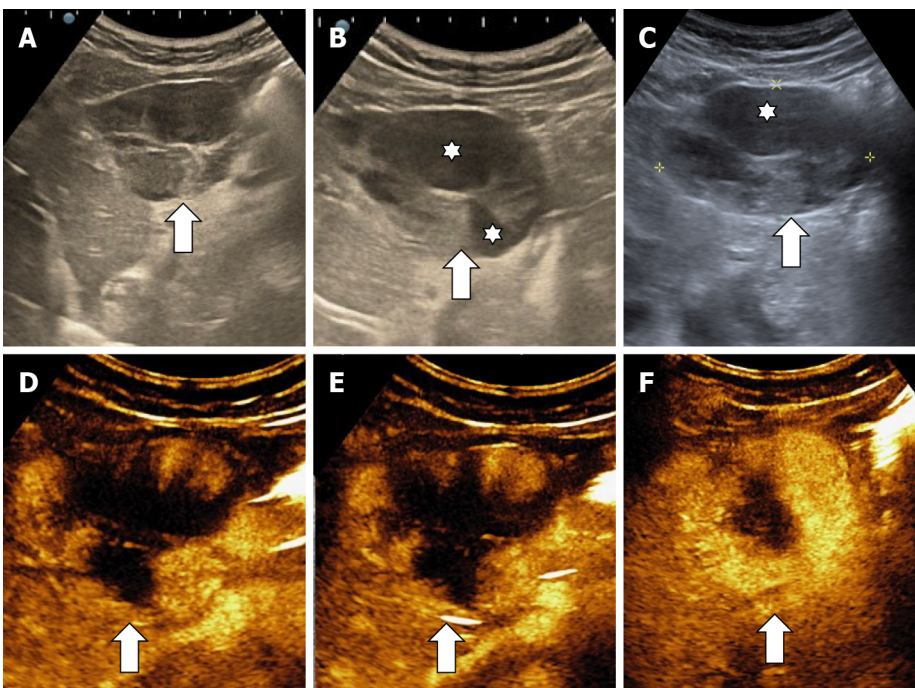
Multicystic hemangioma. A-C: B mode ultrasound shows an inhomogeneous lesion (A) with central cavity (stars) (B) that contains fluid and septa (C); D-F: In contrast enhanced ultrasound the mass shows a progressive (D and E) but partial filling (F) because of the presence of fluid-like cystic cavities that do not enhance.
